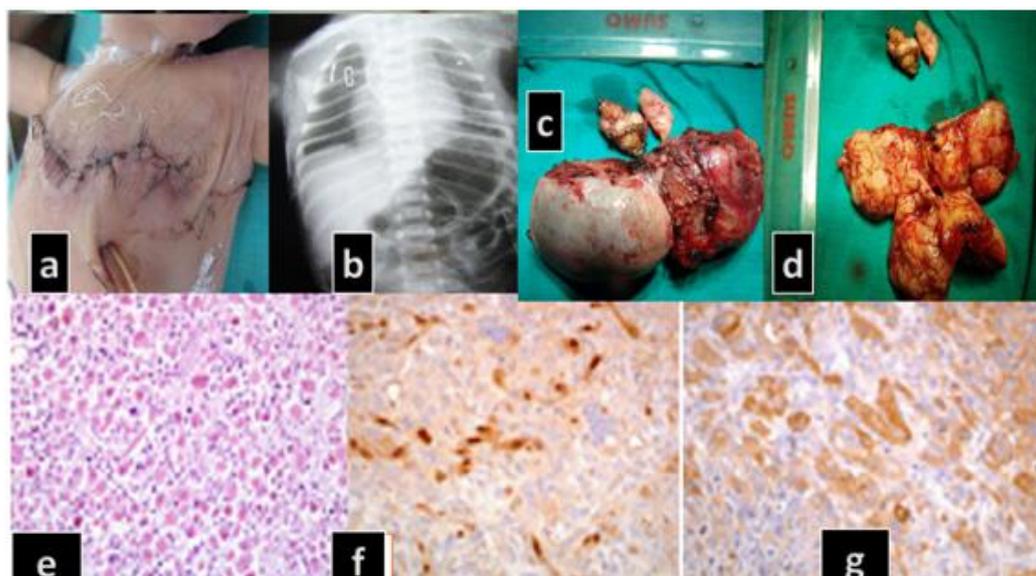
a) Final closure with local advancement flaps, b) Post OP chest radiograph, c) Excised tumor with ellipse of skin, d) Cut surface of tumour showing solid nature, e) Microphotograph showing round cells, f) Desmin and vimentin positive, g) Cytokeratin and S100 negative
